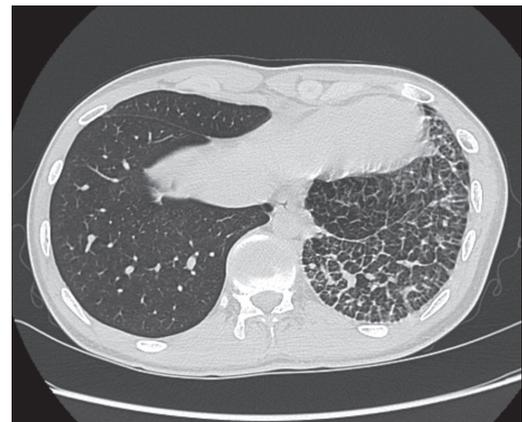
Axial nonenhanced chest CT image showed a small hemithorax with ipsilateral septal thickening and increased tissue attenuation of the left lung
